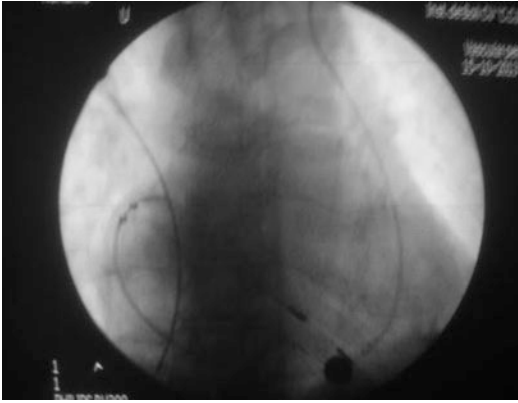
X-Ray—Left superior vena cava pacemaker lead implant (R. Ciudin photo archive)
